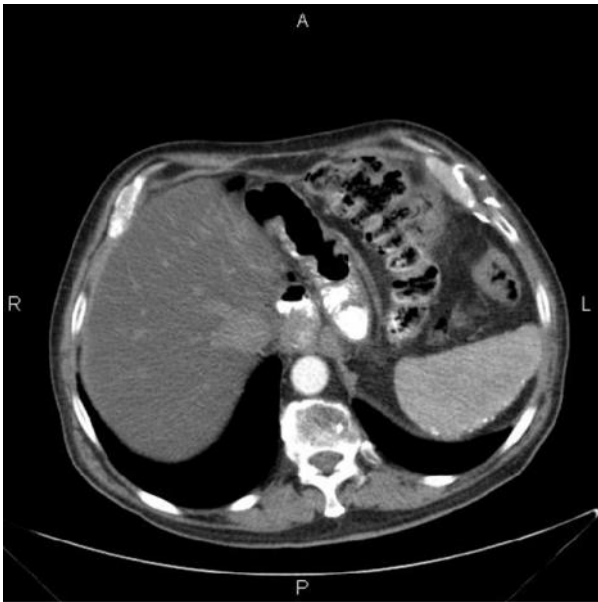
Post procedure CT
